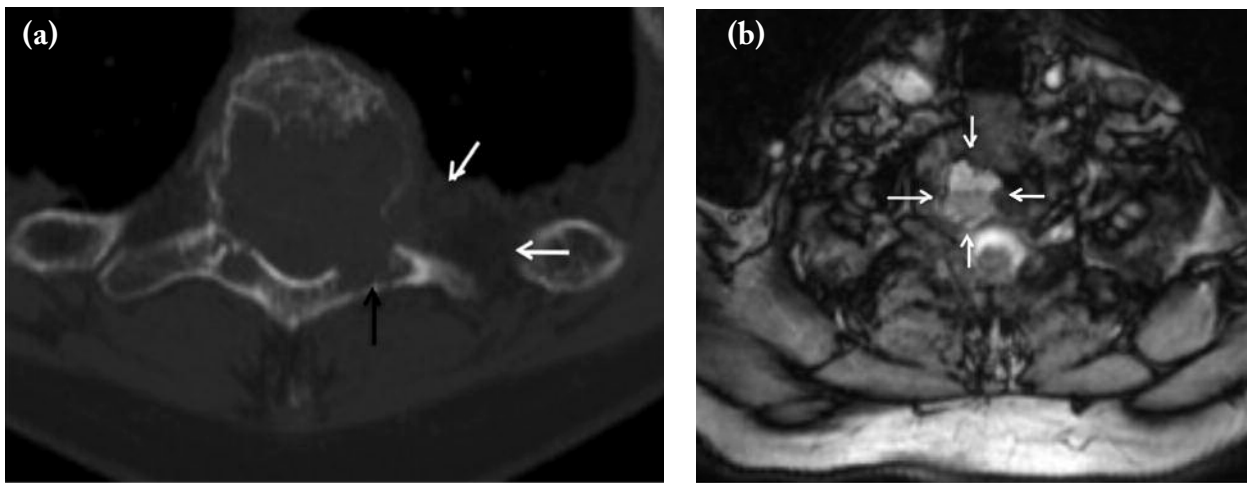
Case 1: a) Axial CT image showing a lytic lesion that extends to the foramen and destroys the front cortex of the lamina. b) Axial T2-weighted MR imaging showing fluid-fluid level in the same cystic lesion.
